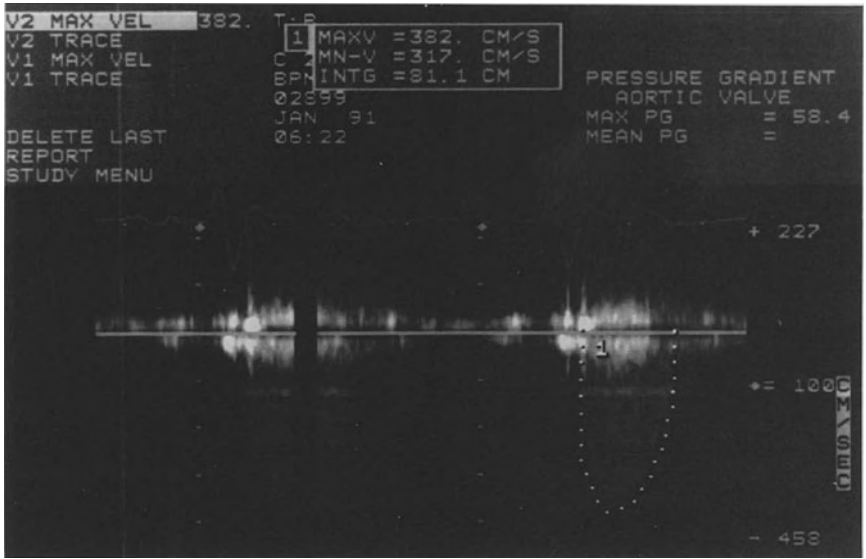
Continuous-wave Doppler recording in aortic stenosis. The aortic valve peak instantaneous gradient ( $p$ ) is 58 mm Hg according to the simplified Bernoulli equation. ( $p = V^2$ ).
